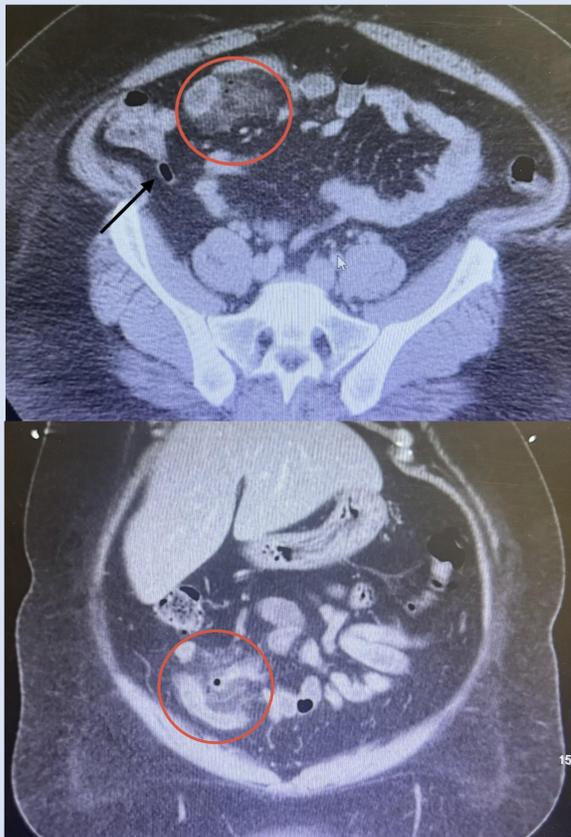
is an axial CT Abdomen and Pelvis showing extensive mesenteric fat stranding in right-lower abdomen. Meckel's diverticulitis (circled) is suggested having indistinct walls, mild wall thickening and tiny locules of free air near its tip suggestive of perforation. Surrounding small bowel loops are fluid-filled which may be due to reactive ileus. Normal sized appendix (arrow). Figure 2 is a coronal CT view showing Meckel's Diverticulum (circled).
